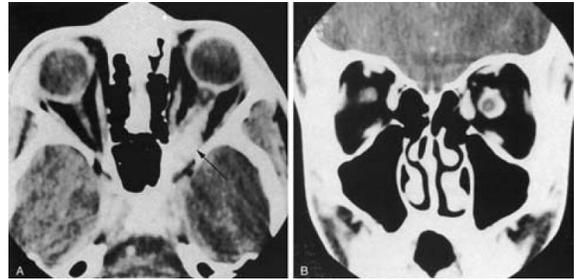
Axial and coronal images of CT scan orbit showing high density mass around optic nerve, favoring left optic nerve meningioma.
